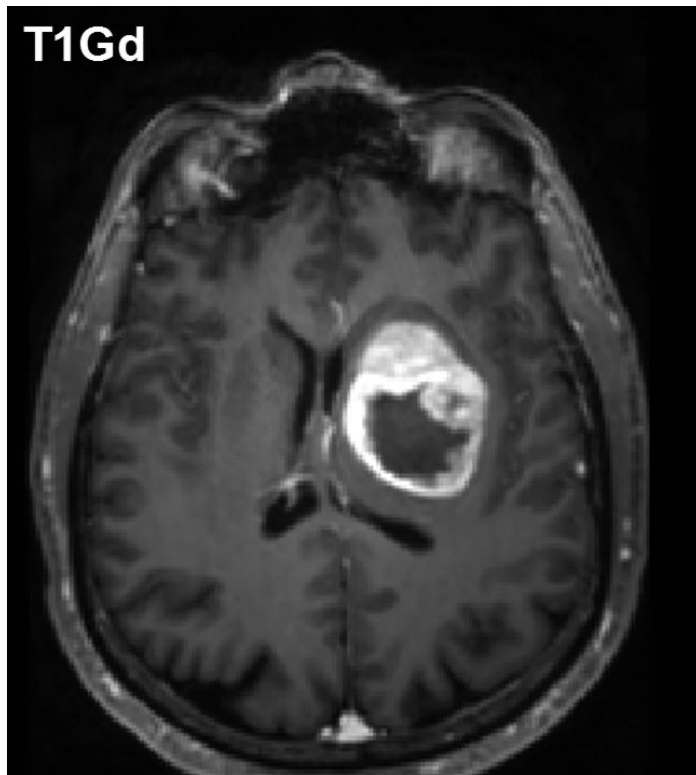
DWI contrast at high b-value in a 61yo patient with a GBM. (A) DWI of the brain typically performed at b-value=0, 1000s/mm², although conspicuity of cellular dense central tumor increases at higher b-values. (B) Tissue has multiexponential diffusion decay properties as is evident by curvature in log(signal) with b-value which can be fit by a bi-exponential function to yield fast diffusion D1, slow diffusion D2 coefficients and relative fraction of fast diffusion component f. (C) The stretched exponential is an alternative functional form to fit multiexponential decay, where DDC is the distributed diffusion coefficient and a lower α value indicates greater heterogeneity of diffusion contributions in the curve. Both the bi-exponential and stretched exponential fits indicate there is a greater spread in diffusion values in tumor relative to normal grey matter for this patient.
